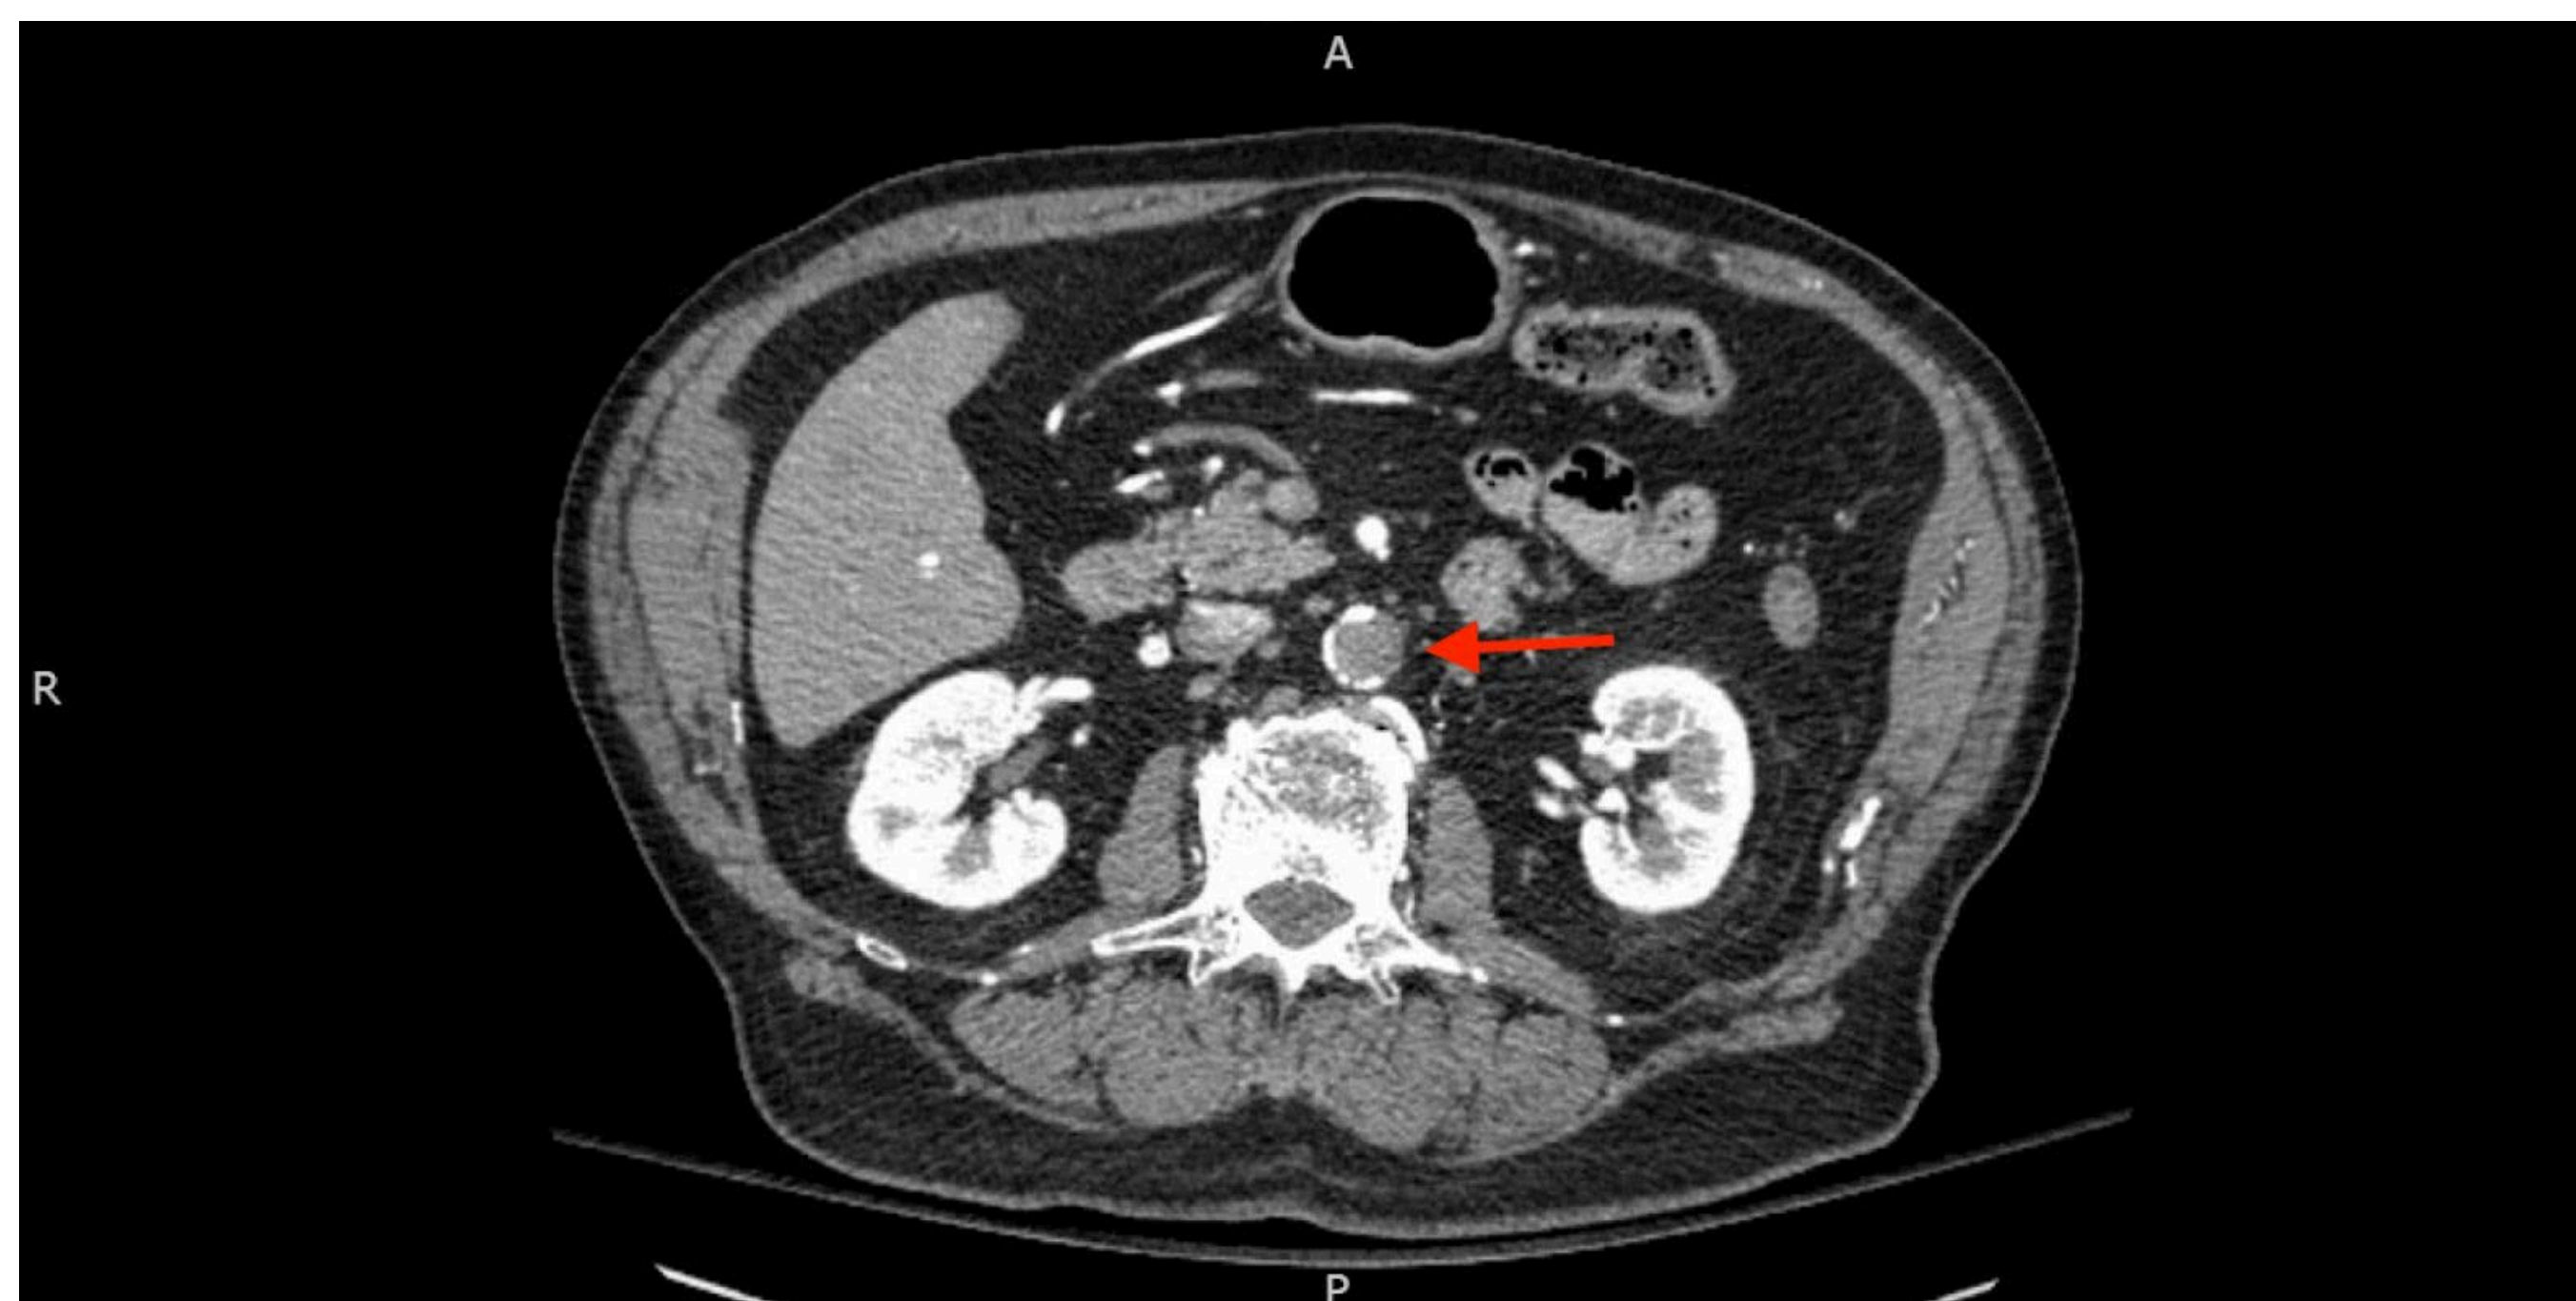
CTA abdomen pelvis transverse plane
